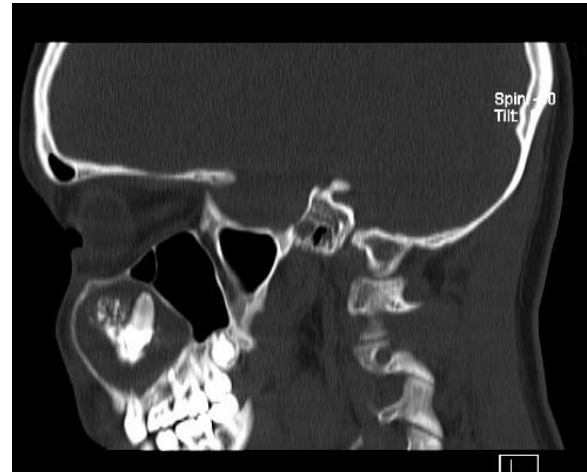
Sagittal CT scan of the patient showing well circumscribed lytic lesion arising from the left maxilla causing expansion and thinning of the maxillary cortex.
